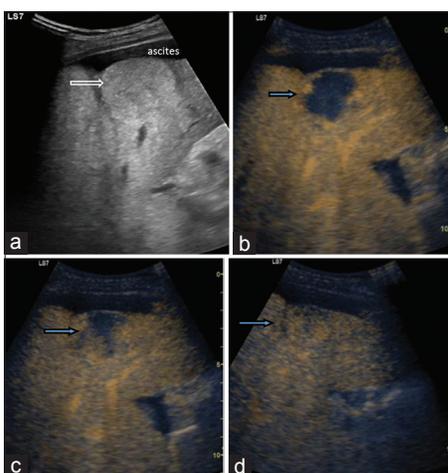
A 58-year-old case of chronic parenchymal liver disease. Ultrasound shows iso to hyperechoic lesion in the left lobe of the liver in the subcapsular region (open white arrow, a). Contrast-enhanced ultrasound is done targeting the lesion showing peripheral nodular enhancement in arterial phase at 20 s after contrast injection (open arrow, b), gradual centripetal filling in venous phase at 85 (open arrow, c), and near-complete enhancement after 232 s (open arrow, d). The lesion was confirmed as hemangioma and is on follow-up. AFP was normal, and there was no e/o diffusion restriction with mean apparent diffusion coefficient value $1.6 \times 10^{-3} \text{ mm}^2/\text{s}$
